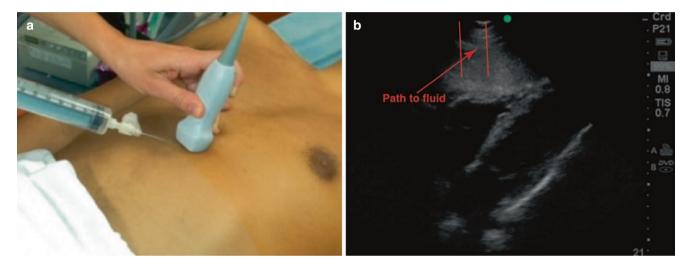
Subcostal approach (a) and corresponding ultrasound image (b). Red line through the liver to obtain fluid (no fluid present on ultrasound image)
